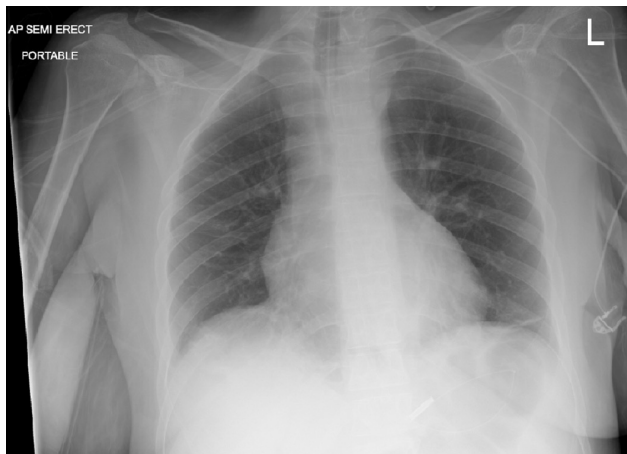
Chest X-ray post PICC line insertion
